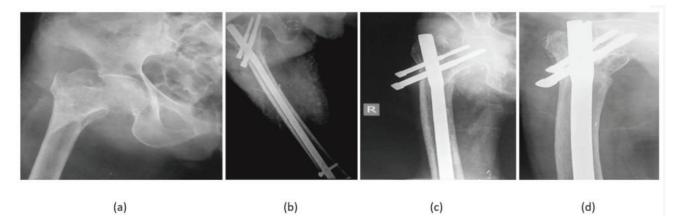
a: Radiograph of left hip showing AO31A2.2 fracture.
